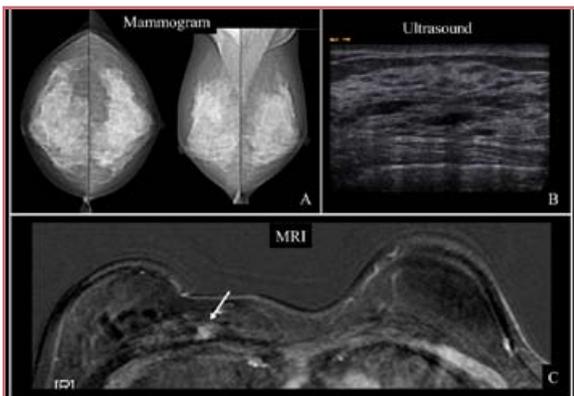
Patient with BRCA2 (A) Normal mammogram (B) Normal ultrasound (C) Breast MRI showed enhancing lesion right breast near chest wall. Biopsy proven DCIS
